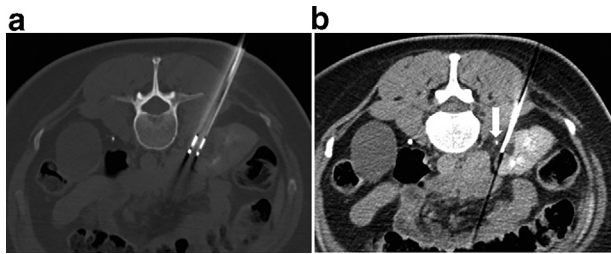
Intra-procedural axial CT during CT-guided CRYO showing (A) two parallel placement of the cryoprobes into the renal tumour close to the PUJ on bone window and (B) the third inferior cryoprobe which was sited close to the proximal ureter (white arrow). The ice ball engulfed the ureter inadvertently during CRYO treatment.
